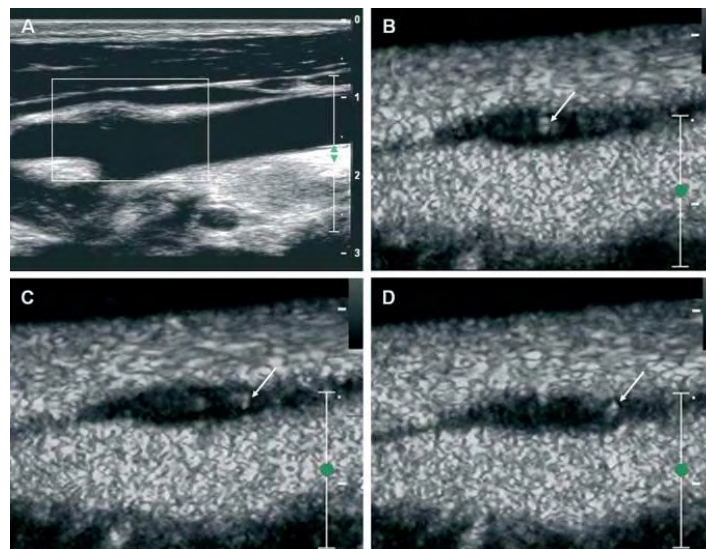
Carotid artery with plaque neovascularization on contrast-enhanced ultrasound imaging.
